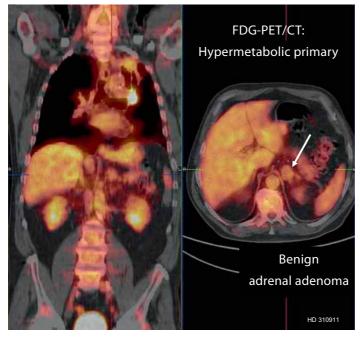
Enlarged adrenal gland (adenoma) in a patient with lung cancer – a diagnostic challenge for CT. FDG-PET can clearly differentiate between benign changes and metastatic lesions based on the glucose consumption (see also fig. 1B).
